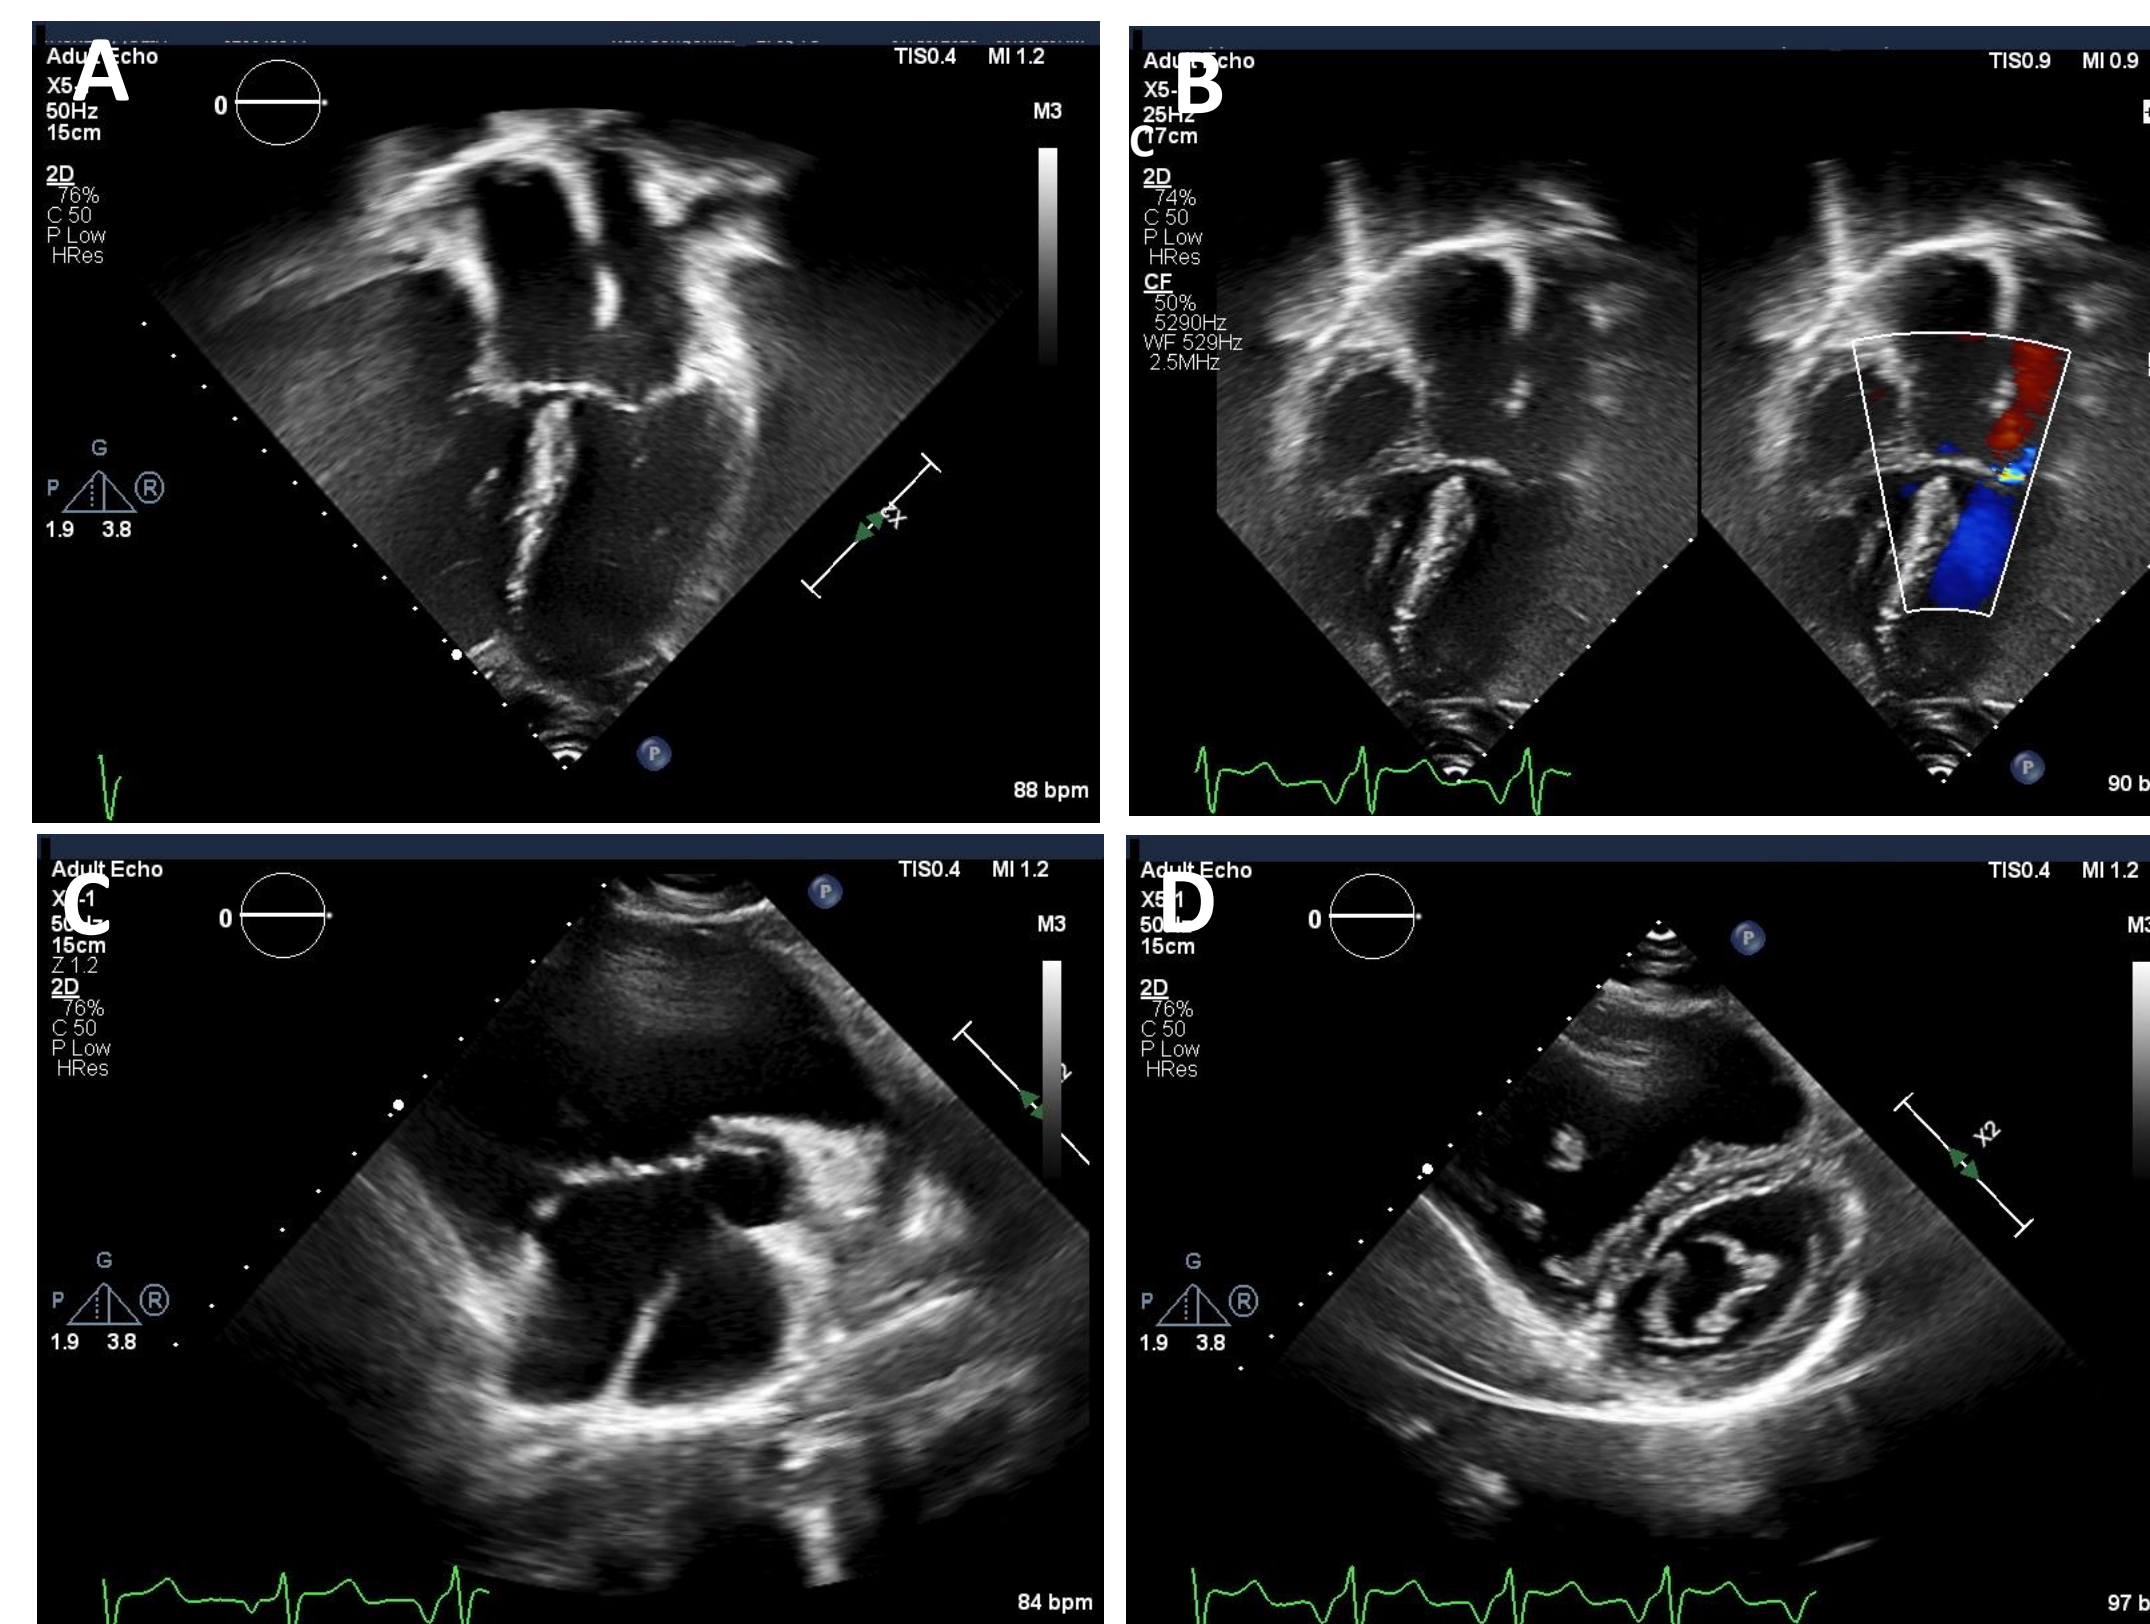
A) and B) show Partial Atrioventricular Canal with Primum ASD and cleft mitral valve, no VSD via apical imaging. C) Parasternal imaging of primum ASD, D) Parasternal short depicting mitral valve cleft.
